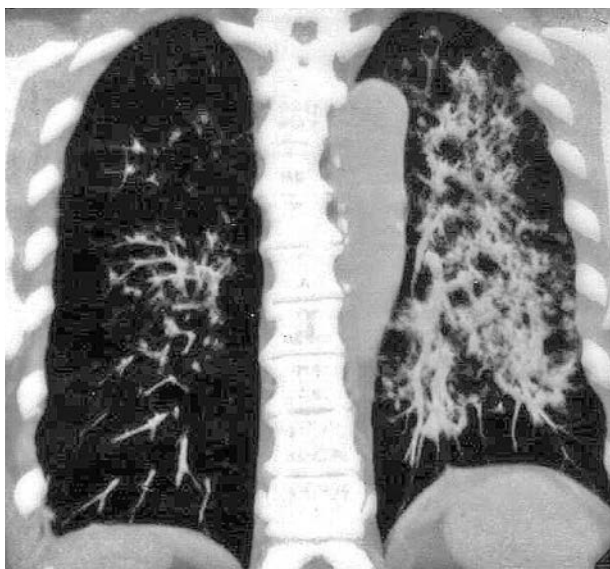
Disseminated pulmonary tuberculosis on chest CT
